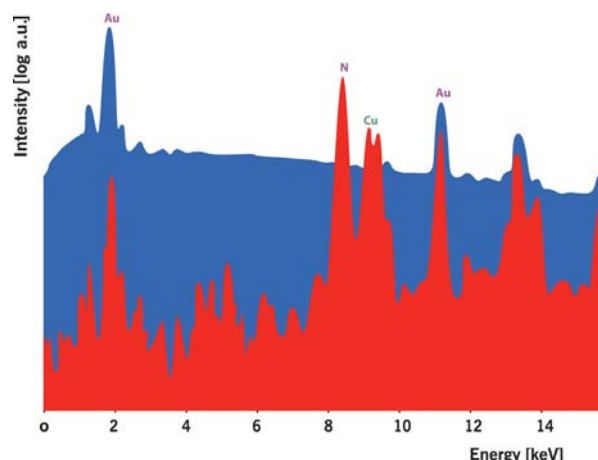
X-ray excitation (red) does not suffer the bremsstrahlung background of electron excitation (blue), enabling much higher sensitivity
